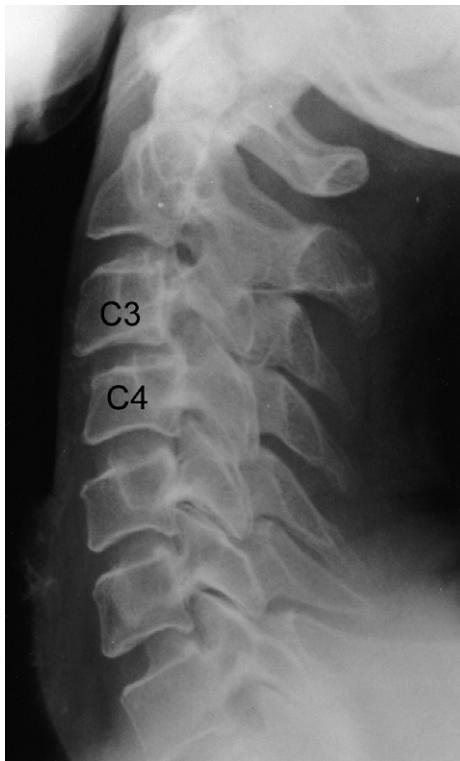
The cervical spine extension plain X-ray image showed no significant movement of C3 on C4 but showed that retrolisthesis of C4 on C5 occurred.
